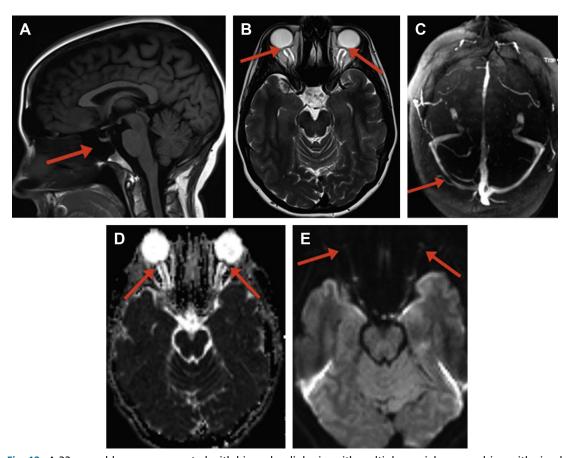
A 32-year-old woman presented with binocular diplopia, with multiple cranial nerve palsies, with visual loss and headache. Patient underwent a diagnostic lumbar puncture with elevated intracranial pressure diagnosing pseudotumor cerebri or idiopathic increased intracranial hypertension. (*A*) Sagittal T1 MR imaging. Arrow points to a partially empty sella. (*B*) Axial T2 MR imaging. Arrows demarcate enlarged optic nerve sheaths and flattening of the posterior globe margins with papilledema. (*C*) Magnetic resonance venography with arrow pointing to the flattened right transverse sinus. (*D*, *E*) ADC and DWI images with arrows pointing to the restricted diffusion at the optic nerve heads consistent with papilledema.
